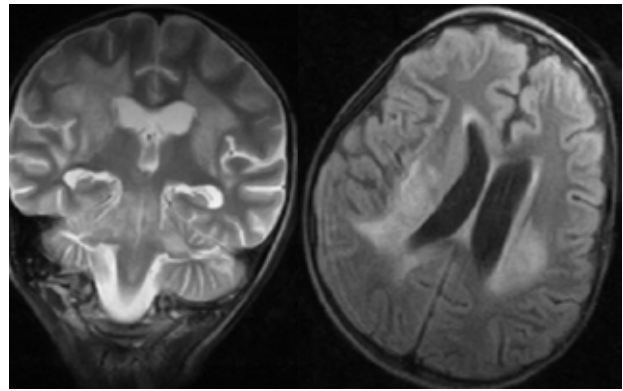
Extension of T2 and FLAIR hiperintensity signal areas into the white matter of the hemispheres in the parietal regions. Moderate dilatation of ventricles V1, V2, V3, V4
